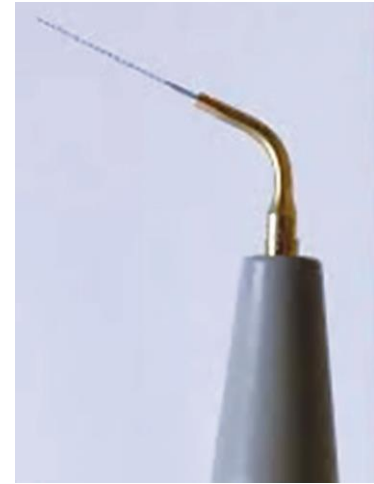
Ultrasonics system
